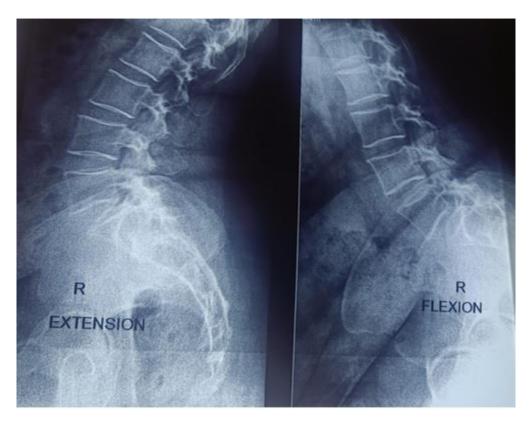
X-Ray Flexion Extension of the same patient showing significant anterolisthesis of L5 over S1 vertebra
